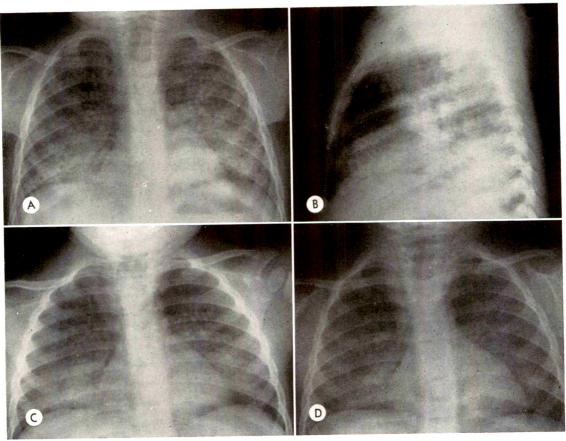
Case III. (A) April 23, 1964: Frontal roentgenogram 4 days following ingestion of furniture polish showing severe involvement of the lower lobes primarily, with mottled densities in the upper lobes also. (B) April 23, 1964: Lateral roentgenogram showing areas of consolidation in lower lobes and perihilar areas. (C) April 27, 1964: Frontal roentgenogram 4 days later showing considerable resolution of the pneumonitis. (D) May 4, 1964: Further clearing seen on frontal roentgenogram 7 days later with some residual densities remaining in the lower lobes.
